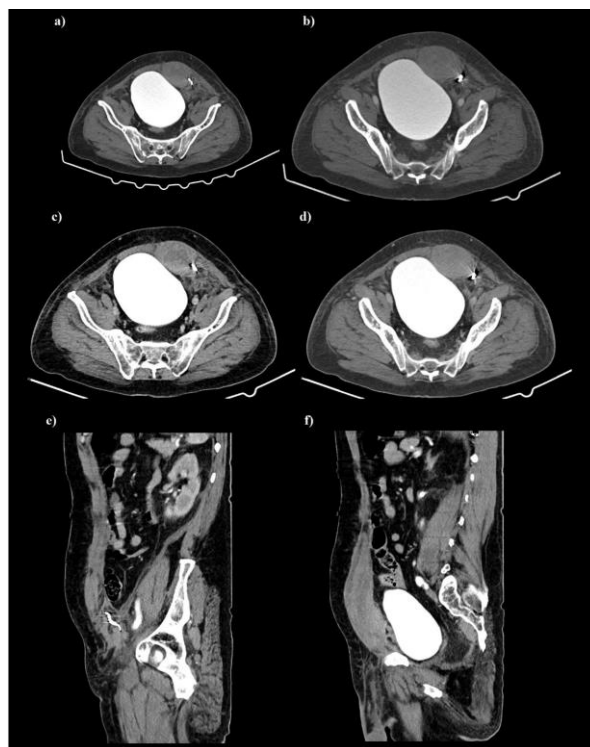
The control abdominal CT with contrast demonstrates the placement of the coils, downsized hematoma, but also a distended bladder filled with contrast: a) and b) represent the arterial phase; c) and d) represent the venous phase; e) and f) represent the saggital reconstruction
